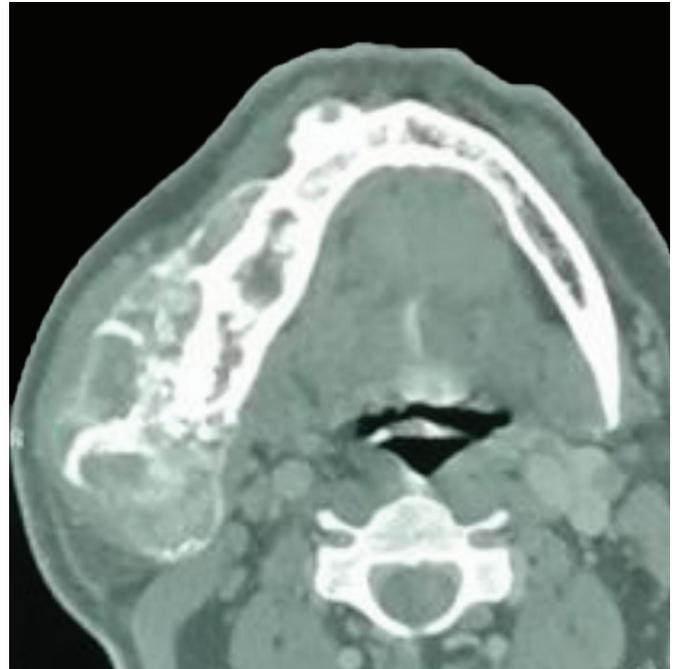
Computed tomography image axial view
